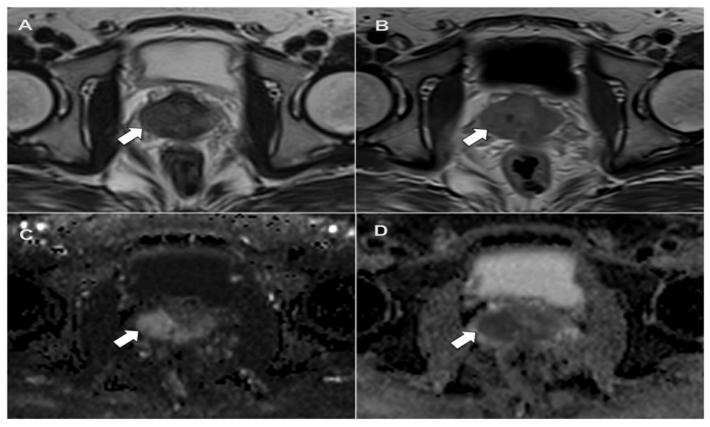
Axial MRI images of the pelvis demonstrating a lesion within the right side of the prostate (white arrow). This lesion shows intermediate signal in T2-Weighted sequence (A), minimal enhancement on post gadolinium T1-Weighted sequence (B) and diffusion restriction on Diffusion-Weighted sequence (C & D)
